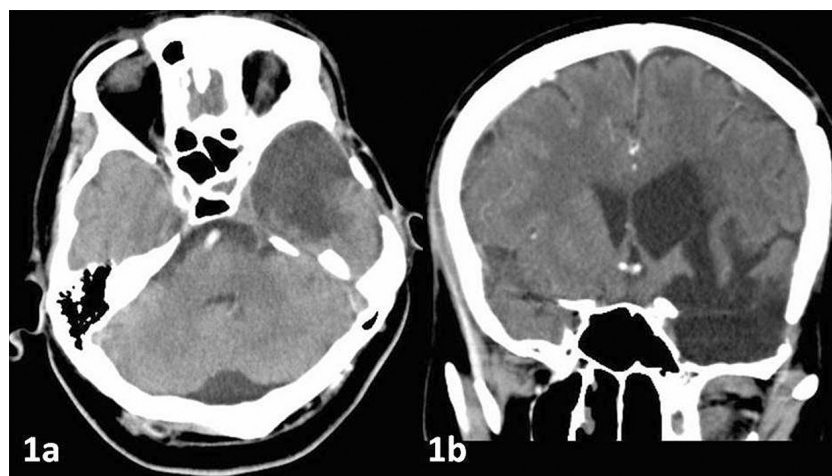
Tissue loss at the left temporal lobe, encephalomalasic areas and changes secondary to surgery as well as dilatation at the left lateral ventricle secondary to tissue loss are seen on CT scan (axial-a, coronal-b).
